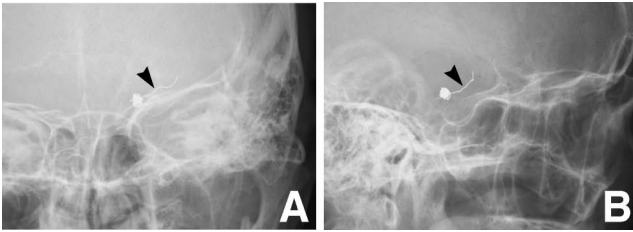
Skull radiographs, Town's (A) and lateral views (B), on day 24 showing the migrated coil portion (arrowhead).
